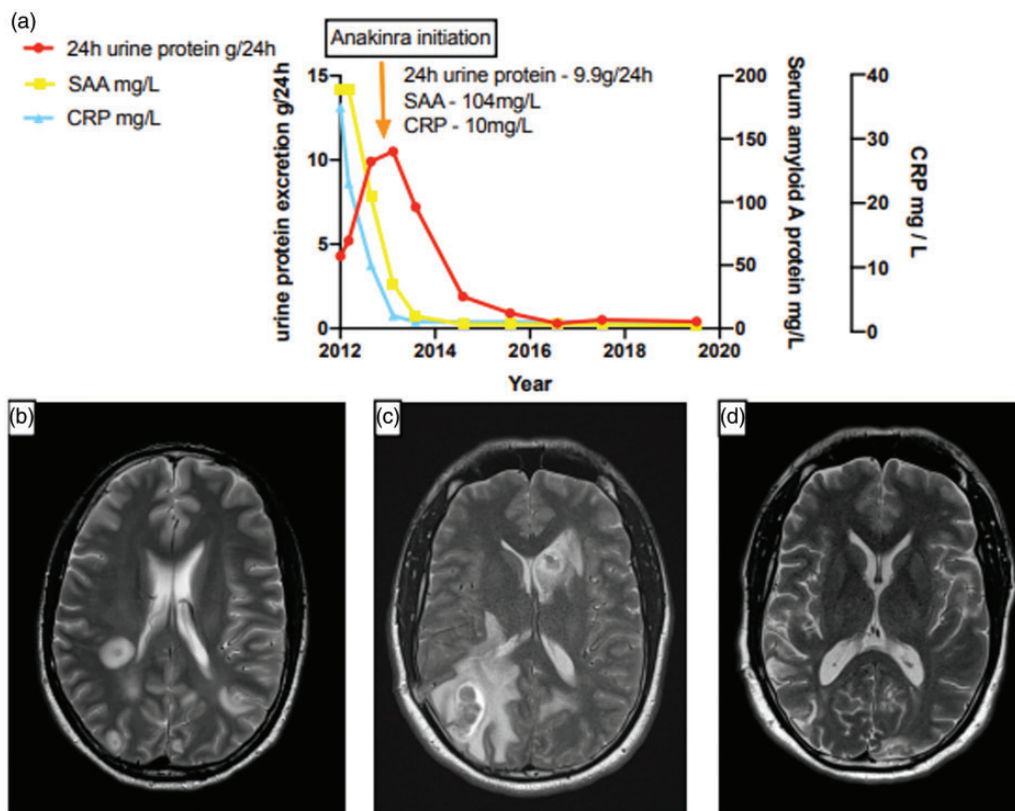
(a) Case 1 – Graph demonstrating progress of 24-h urine protein excretion, serum amyloid A (SAA) protein and serum C-reactive protein (CRP) before and after initiation of anakinra therapy. Case 2 – Serial T2 weighted MRI brain scans at baseline (b), 18 months (c) and three years (d) into illness, demonstrating progressive and unstable tuberculomata throughout both hemispheres until 18 months, with subsequent resolution following anakinra therapy.
